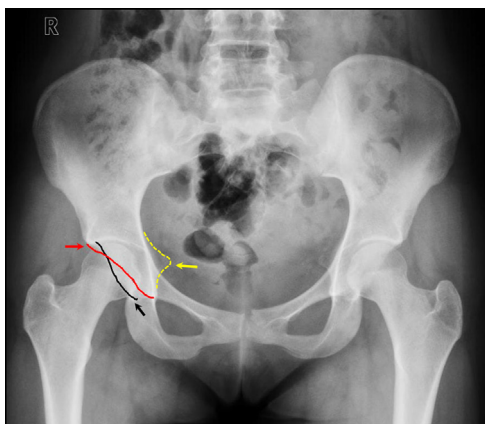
Anteroposterior radiograph of the pelvis with right hip focal anterior overcoverage and acetabular retroversion. The anterior wall (red arrow) and posterior wall (black arrow) form a crossover sign. An ischial spine sign (yellow arrow) is also observed, consistent with acetabular retroversion. (Color version of figure is available online.)
